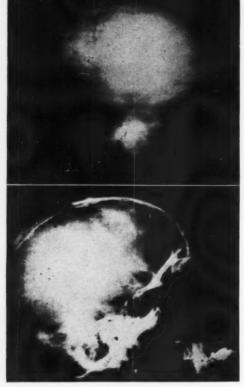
(above). Skull fracture. Contra coup. To impress the importance of making roentgenograms of both sides.
